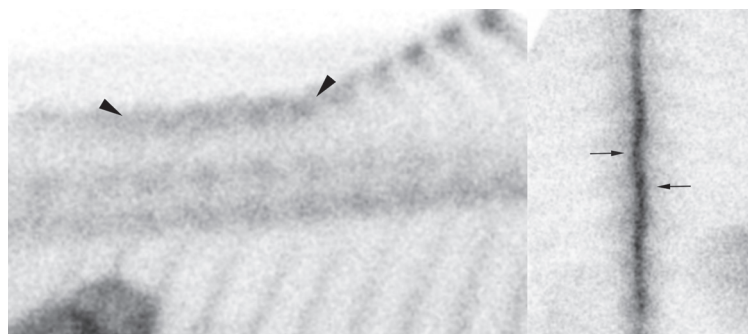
Four-year-old Thoroughbred stallion presented for stiffness and reluctance to move. Bone phase scintigraphy showed mild increased radiopharmaceutical uptake in the summit of the mid thoracic spinous processes (arrowheads) and misalignment (arrows) suggestive of impinging and overlapping spinous processes.
